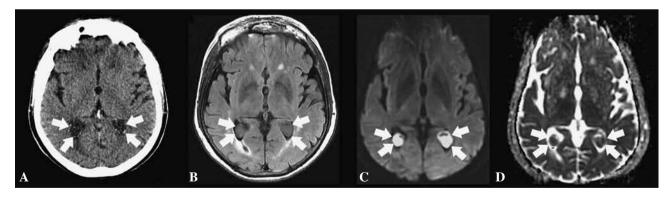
CT showing ventricular cysts with peripheral calcifications (A). On MRI, they are hyperintense to CSF on FLAIR (B), DWI hyperintense (C), with ADC values close to those of white matter (D).
